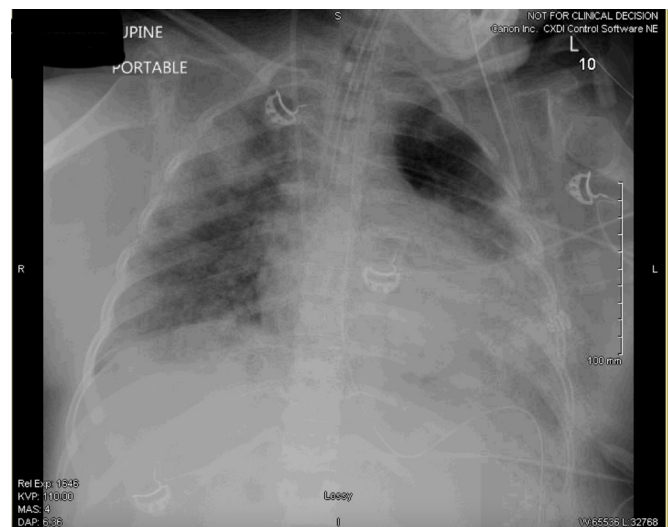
Anteroposterior chest x-ray showing bilateral multifocal airspace consolidation.
